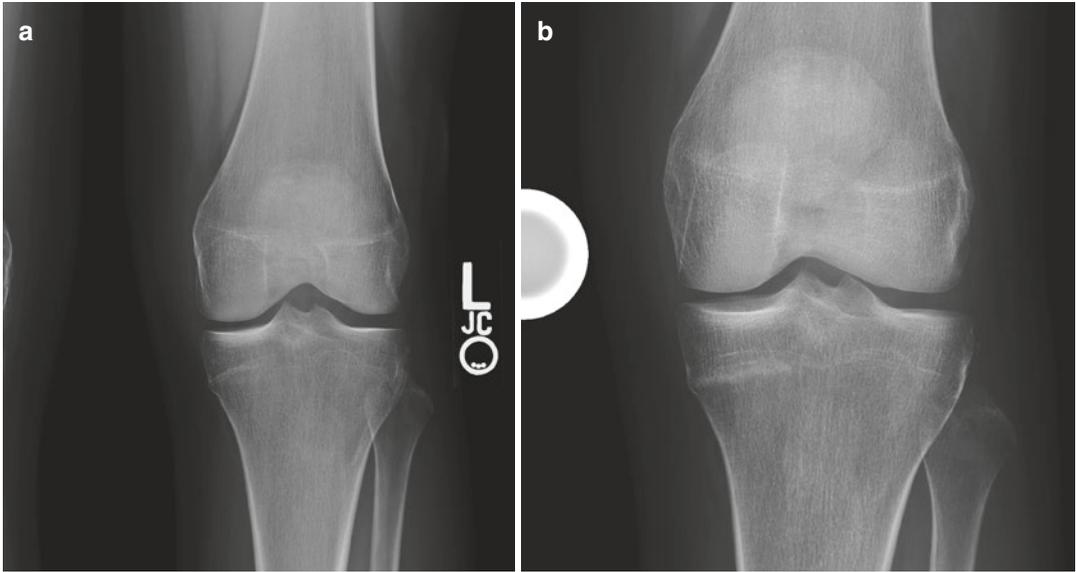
(a and b) AP plain films of the left knee showing an occult fracture on presentation (a) and 3 weeks later a healing stress fracture in the medial proximal tibia (b)
